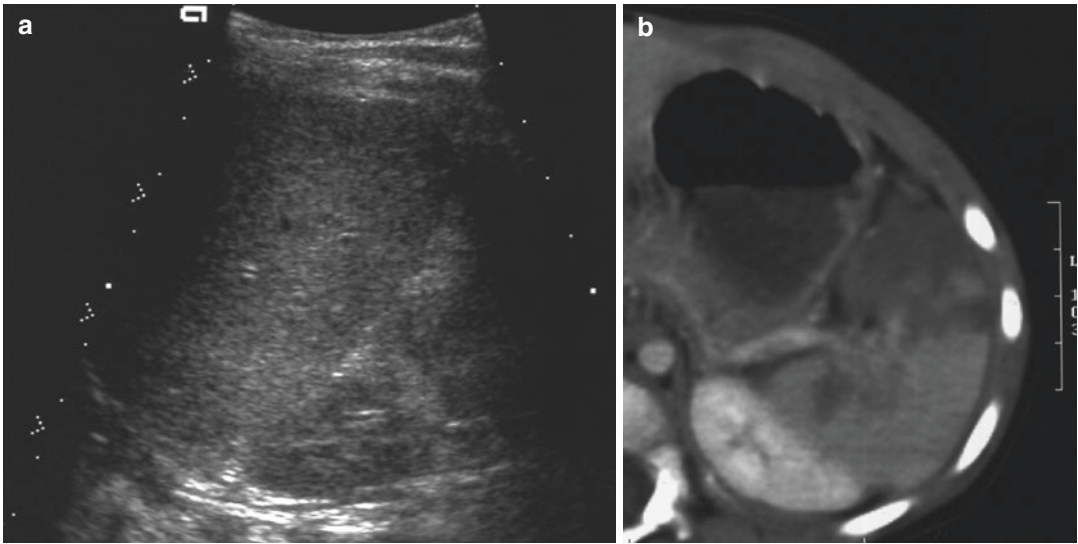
Two year old girl. Direct abdominal trauma by the fall of a supermarket trolley. (a) US longitudinal scan: heterogeneous spleen with no visualization of the hilum. (b) CT with contrast: spleen injury under estimated by US
